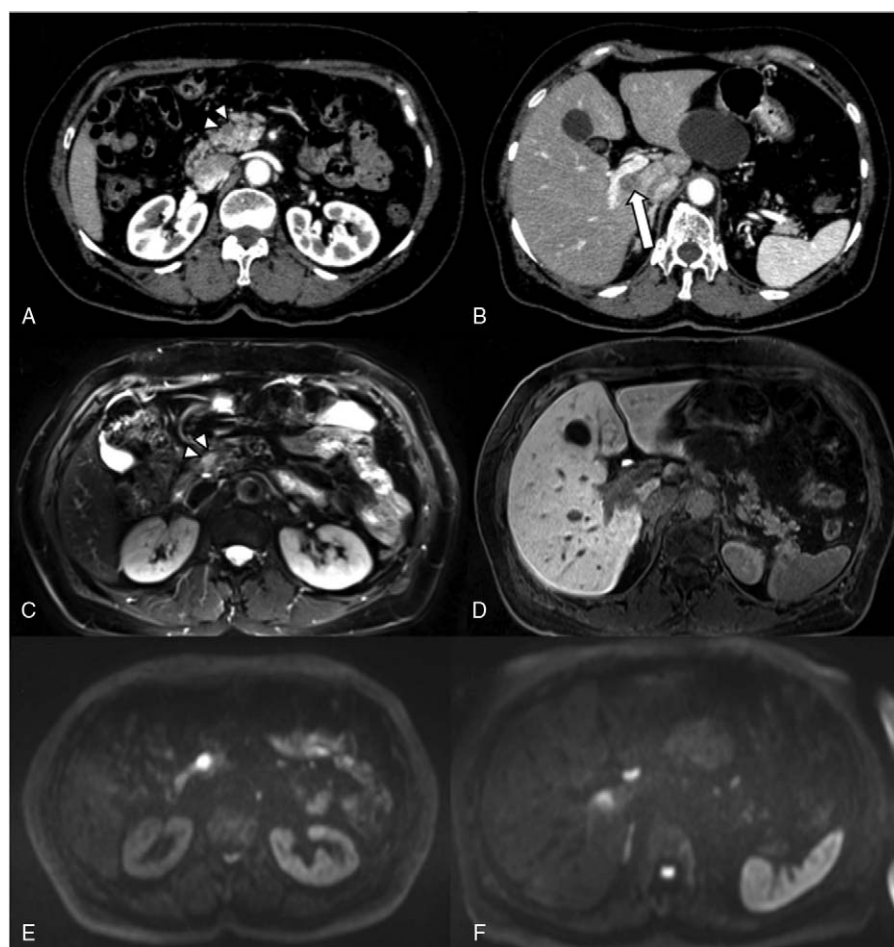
Findings of contrast-enhanced computed tomography (CECT) and Gd-EOB-DTPA-enhanced magnetic resonance imaging (EOB-MRI). (A) The CECT scan revealed a 9 mm poorly enhanced nodule in the head of the pancreas (white arrowheads). (B) A 14 mm poorly enhanced nodule is present in the caudate lobe of the liver (white arrow). (C) EOB-MRI revealed that the pancreatic nodule exhibits hyperintensity on T2-weighted imaging (white arrowheads). (D) The hepatic nodule demonstrated hypointensity in the hepatobiliary phase (white arrow). (E and F) The pancreatic nodule and hepatic nodules exhibited high signal intensity on diffusion-weighted MRI.
